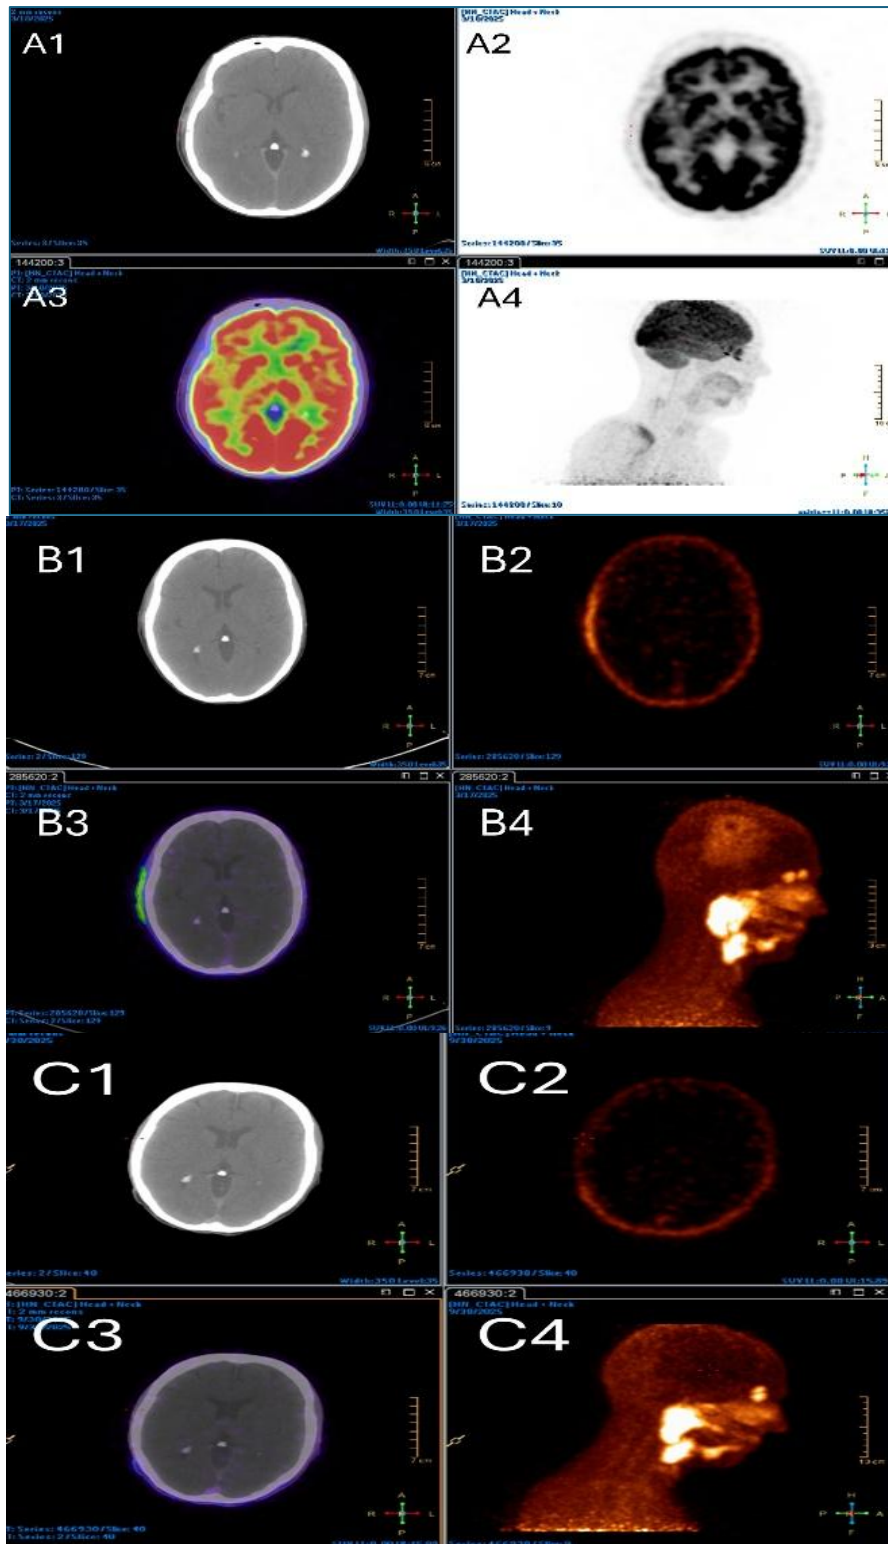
(A-C): Pre- and post-operative nuclear medicine imaging. A: Selected images from the staging ^{18}F -FDG PET/CT showing no significant FDG uptake in the primary tumour. 1) Low dose axial CT, 2) Axial PET images alone, 3) Fused axial PET-CT images and 4) Sagittal maximum intensity projection. B: Selected images from the staging ^{68}Ga -PSMA-PET/CT showing moderately increased tumour related tracer uptake in right fronto-parieto-temporal scalp region: 1) Low dose axial CT, 2) Axial PET images alone, 3) Fused axial PET-CT images and 4) Sagittal maximum intensity projection. C: Selected images from the post-therapy ^{68}Ga -PSMA-PET/CT showing treatment response with no residual uptake in right fronto-parieto-temporal scalp region. 1) Low dose axial CT, 2) Axial PET images alone, 3) Fused axial PET-CT images and 4) Sagittal maximum intensity projection.
